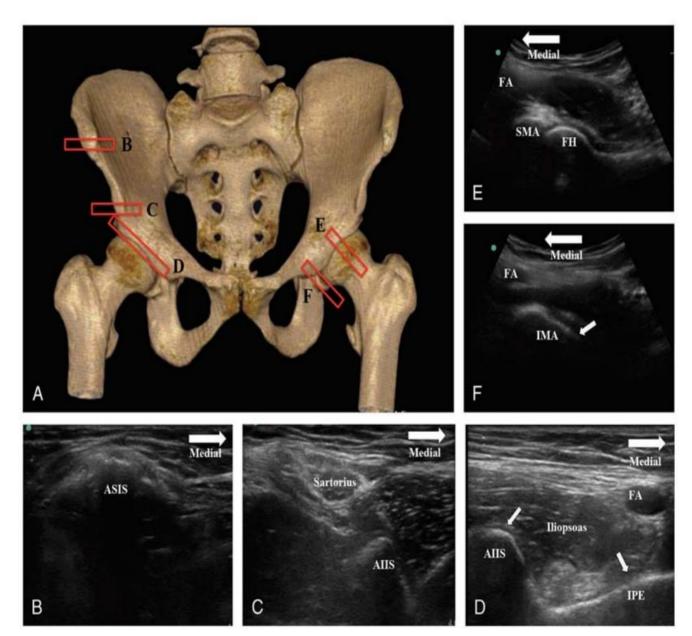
Ultrasound landmarks for image-guided injections of articular branches innervating the anterior hip capsule. A, Skeletal model showing US probe positions (red rectangles). B, Ultrasound image at the level of anterior superior iliac spine (ASIS). C, Ultrasound image at the level of AIIS. D, Ultrasound image aligning the AIIS and iliopubic eminence (IPE). The tendon of iliopsoas muscle is shown as hyperechoic structure at the deep end of the muscle. Femoral artery (FA) is on the medial side of the muscle. E, Ultrasound image aligning the femoral head (FH) and neck with superomedial acetabulum (SMA). F, Moving the US probe medially reveals the inferomedial acetabulum (IMA).³¹
